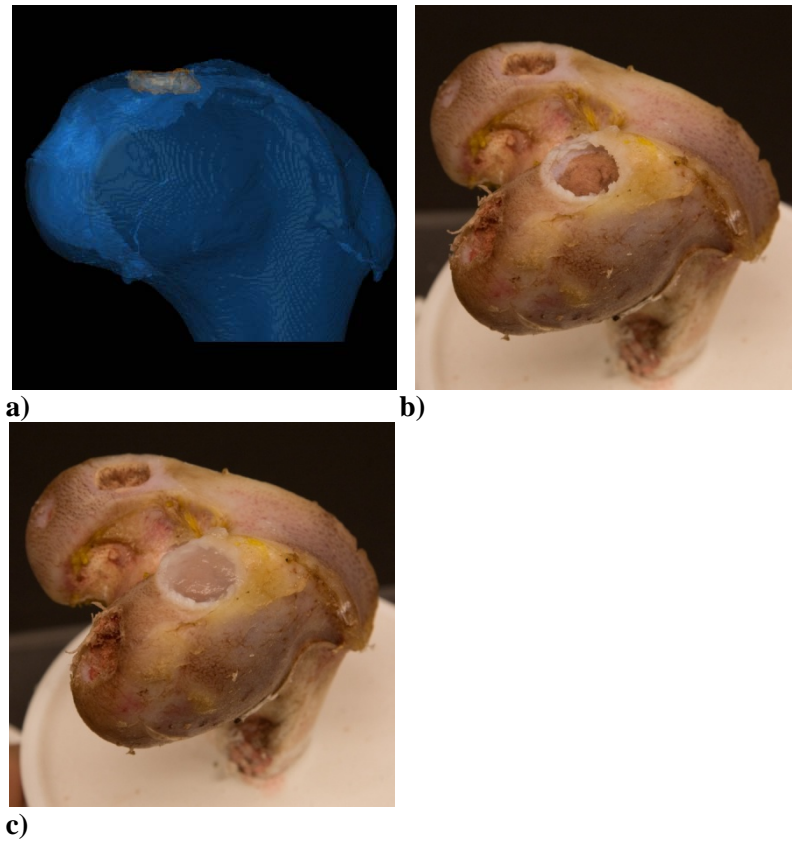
Repair of chondral defect. (a) CT scan of the femur with the chondral defect on the top surface. (b) Chondral defect before repair. (c) Chondral defect after repair.
